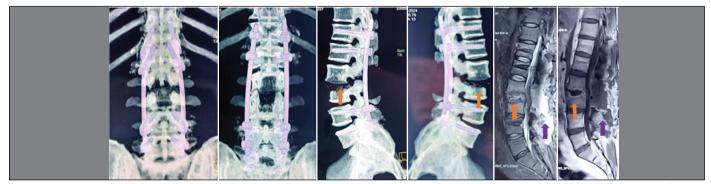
Postoperative CT scan and MRI showing the fixation system with pedicle screws in vertebrae T12, L1, L4, and L5, with lateral rods. There is evidence of further progression of the spondylodiscitis (orange arrows) and the deep seroma (purple arrows).
